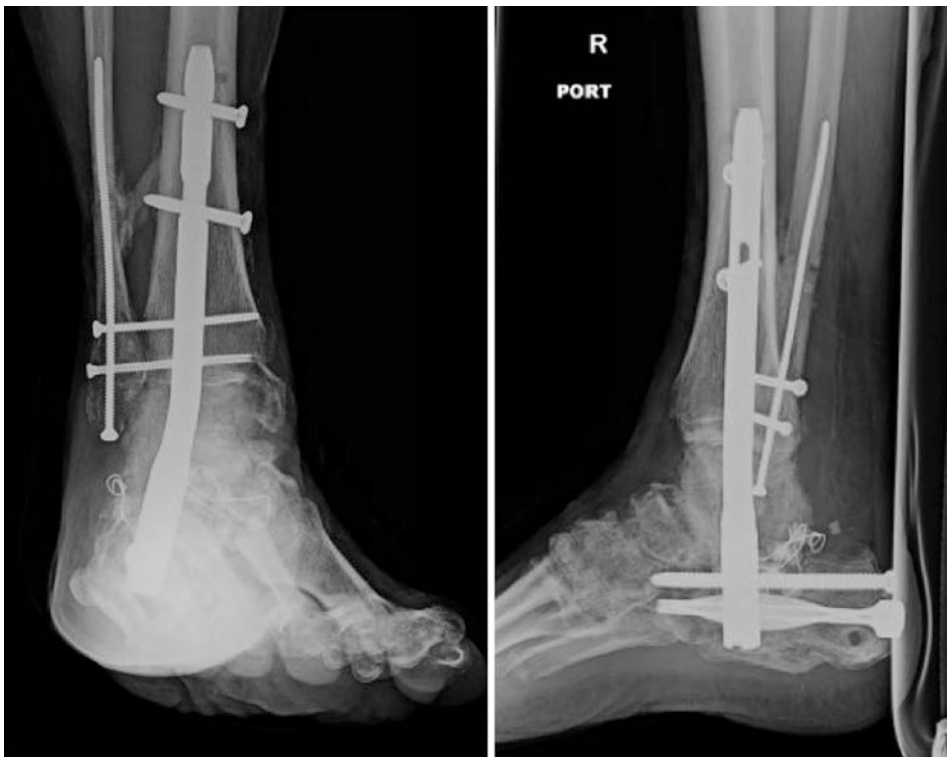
Mortise and lateral X-rays 6 months after injury demonstrate maintained alignment and progression toward fusion
